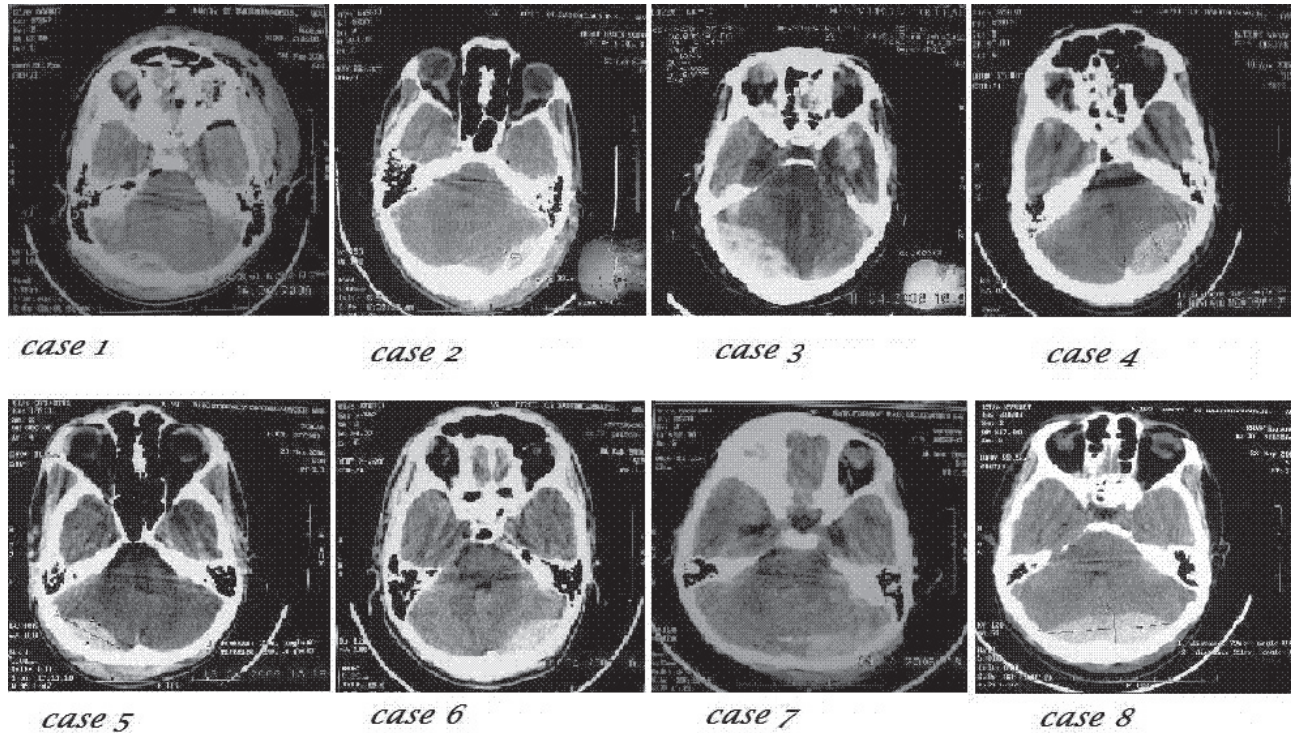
Pre operative axial CT scan (representative posterior fossa cuts) of C. No. 1- 8 showing posterior fossa EDH
